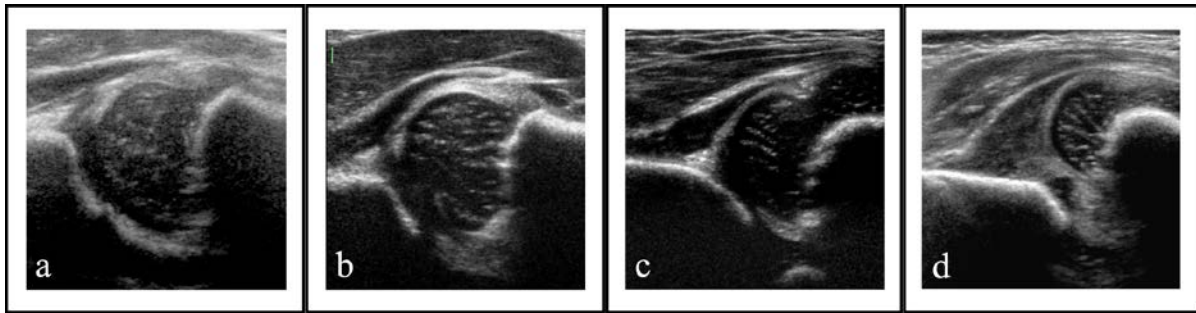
Sonographic assessment of hip stability in newborns. By using a modified Barlow-manoeuvre, hips are classified as a) stable, b) unstable (significant movement of the femoral head, but not dislocatable), c) dislocatable or d) dislocated.
